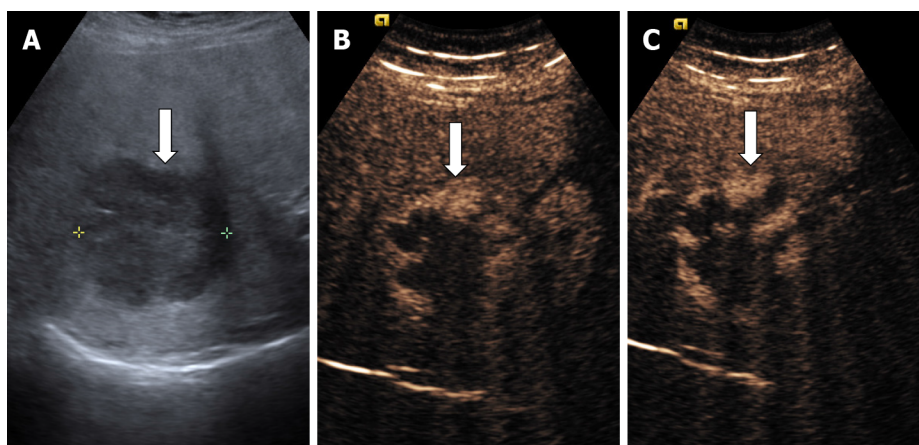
A case of cavernous hemangioma detected in a 64-yr-old man with liver cirrhosis. A: On B mode ultrasound is observed a hyperechoic inhomogeneous liver and a hypoechoic large lesion in the right liver lobe; B: On contrast enhanced ultrasound, the liver lesion shows a typical early, peripheral, globular enhancement; C: In the late phase incomplete enhancement is noticed.
